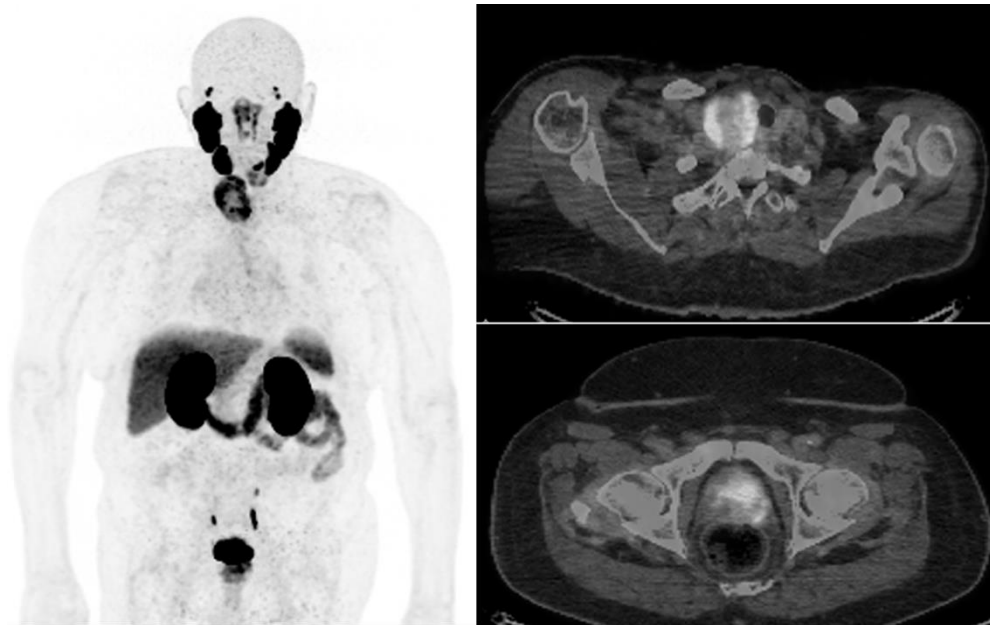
^{18}F -PSMA PET/CT: Axial PET/CT fused (*top right*) and MIP images show heterogenous PSMA uptake in a large right thyroid lobe nodule, subsequently pathology-proven ATC. Axial PET/CT fused image (*bottom right*) shows heterogenous PSMA uptake in the prostate gland, consistent with known prostate cancer.
